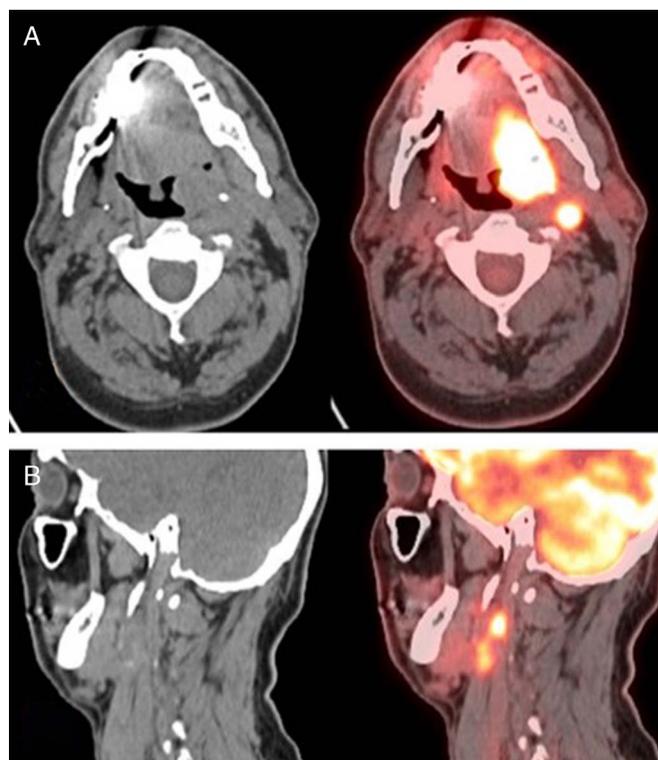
Staging neck nodal metastasis. A 52-year-old man with squamous cell carcinoma of the left tonsil (primary T4). Axial CT and PET/CT fused images (A) demonstrated highly FDG-avid primary tumor and subcentimetric metastatic lymph node at level II. Sagittal CT and PET/CT fused images (B) showed subcentimetric metastatic lymph node at level II and III (T4N1M0).
